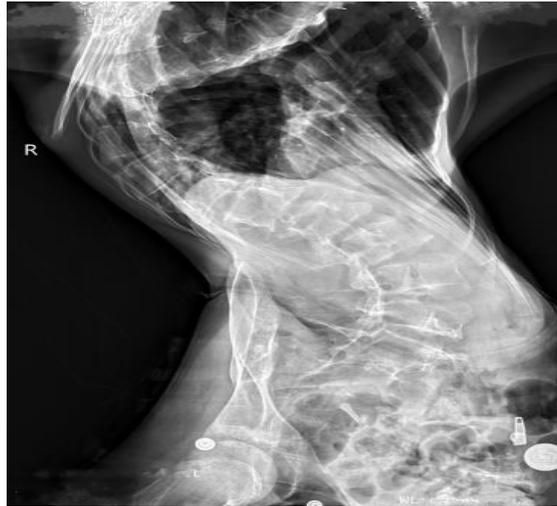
X-ray long spine lateral
